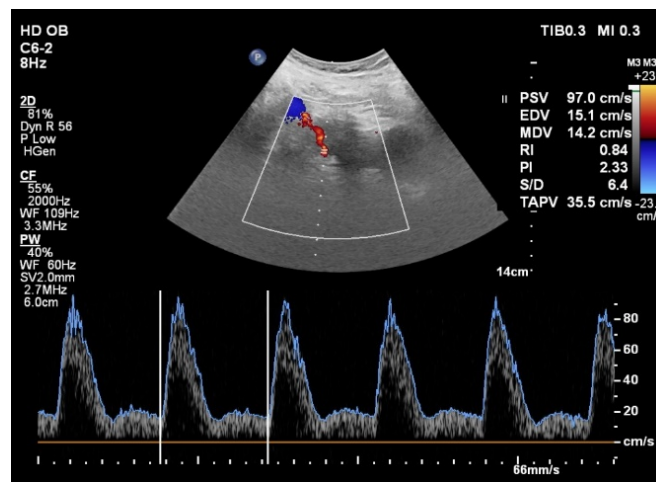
Abnormal uterine artery doppler with high PI and early diastolic notch
